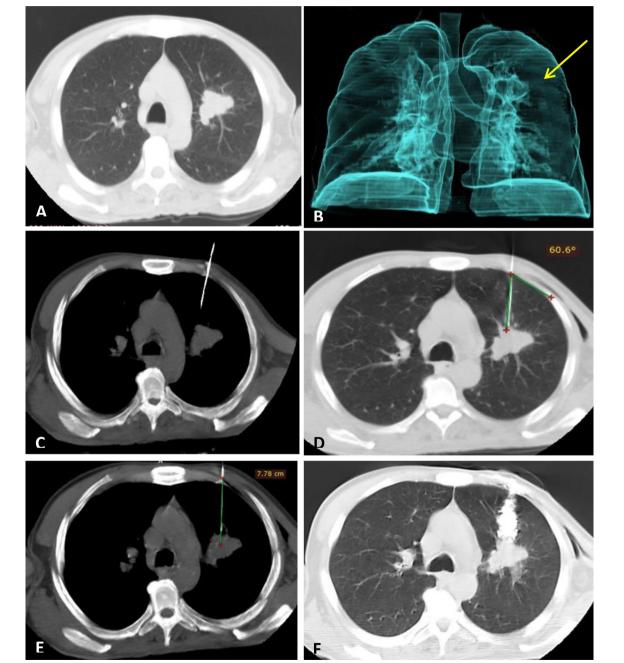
A Axial CT images showing left upper lobe mass. B 3D VR of airways showing encased apicoposterior bronchus (arrow). C Coaxial pass out of trajectory, D Coaxial pass in trajectory, needle pleural angle 65°. Note developing surgical emphysema. E Coaxial pass in trajectory, biopsy track length 7.7 cm. F Gelfoam embolization of biopsy track with no complications
